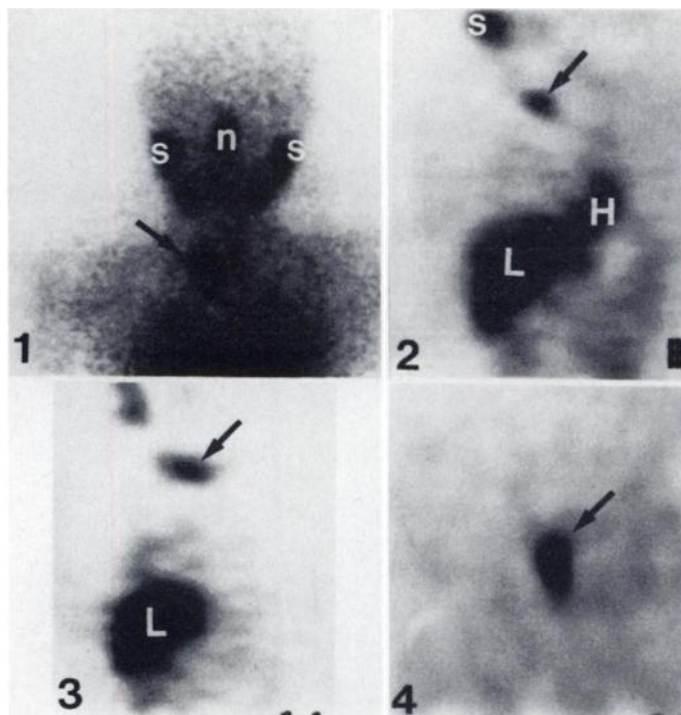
An 8-yr-old boy with residual thoracic neuroblastoma after resection. Iodine-123-MIBG scan at 24 hr (panel 1). Anterior planar image shows uptake into the tumor (arrow) and normal uptake in the salivary glands (s) and nasopharynx (n) (panels 2–4). Coronal, sagittal and transverse SPECT sections show uptake in the tumor (arrow) and normal uptake in the liver (L) and heart (H), and provides three-dimensional localization of the lesion.
